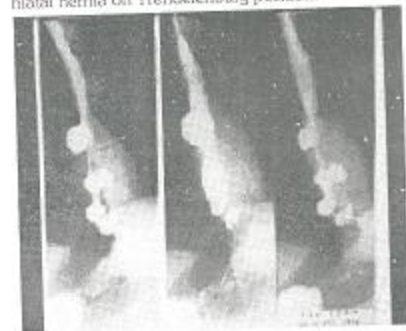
The same diverticula are seen in the radiography taken on decubitus position
